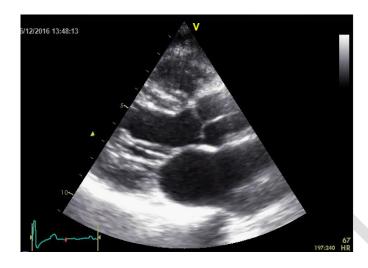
Example of a parasternal long axis (loop should be recorded)
